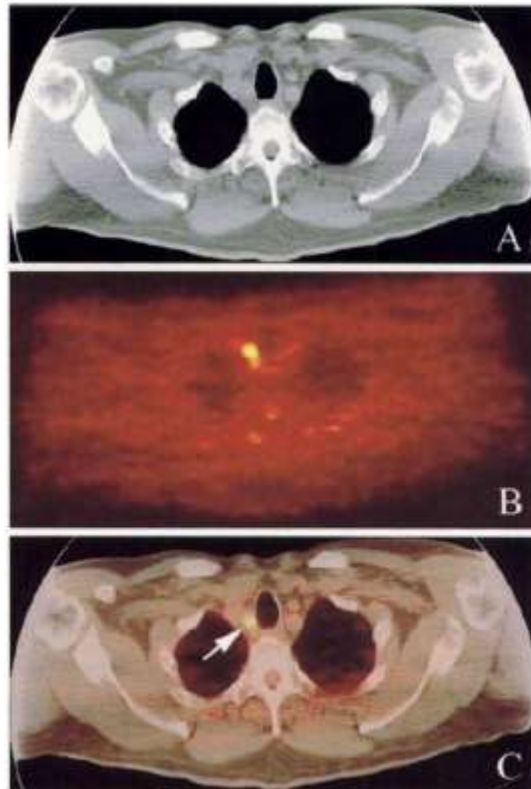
A 69-y-old man with diagnosed primary esophageal adenocarcinoma. (A) CT image. (B) PET image shows abnormal FDG uptake in the thorax. (C) Fused PET/CT image localizes uptake to specific lymph node (arrow).
